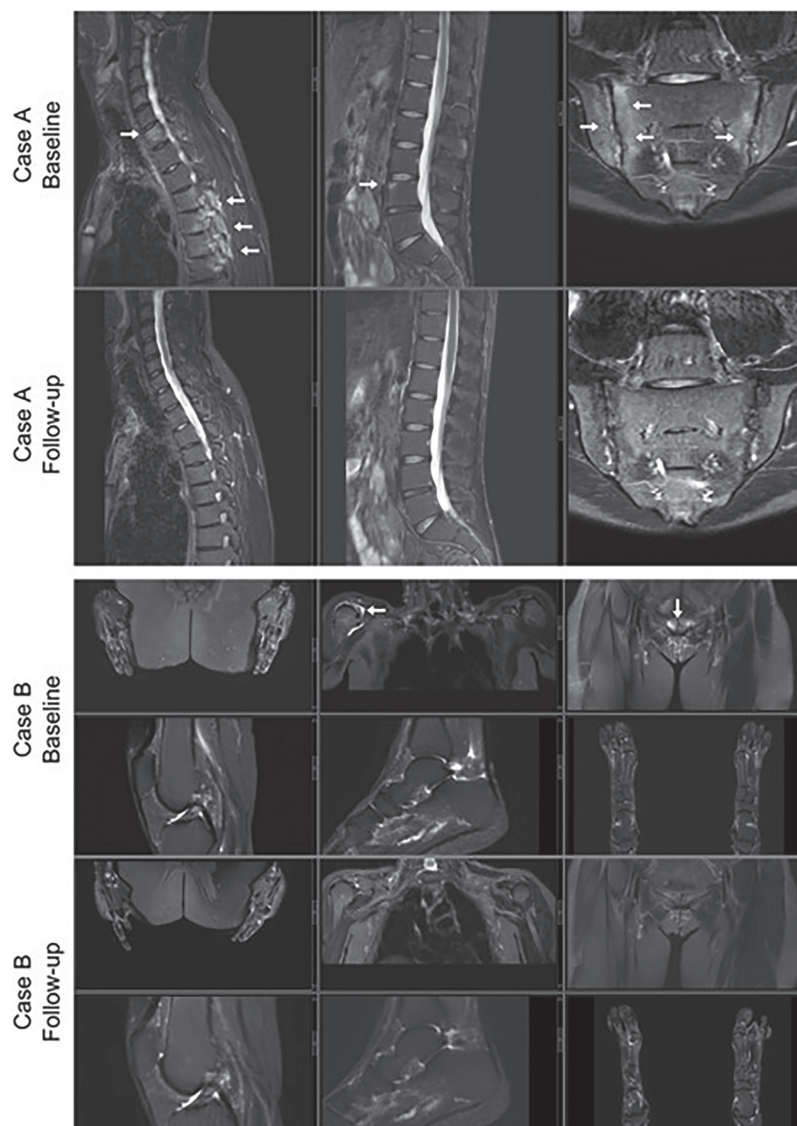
Examples of improvement in axial and peripheral inflammatory lesions documented by whole-body magnetic resonance imaging. Case A: Patient with improvement in axial inflammation. (L-R): Sagittal STIR of upper spine, sagittal STIR of lower spine, and semicoronal STIR of SIJ. Inflammatory lesions in facet joints and lateral parts of vertebral bodies at rib insertions and inflammation of both SIJ at baseline improved during treatment. Case B: Patient with improvement in peripheral inflammation. (L-R): Coronal STIR of hands, coronal STIR of shoulders and anterior chest wall, coronal STIR of pelvis, sagittal STIR of knees, sagittal STIR of ankles, and coronal images of feet. Synovitis and/or effusion in the right glenohumeral (shoulder) joint and osteitis at the pubic symphysis at baseline improved during treatment. Arrows indicate bone marrow edema (inflammation). Reprinted with permission from Krabbe et al.²⁵ SIJ: sacroiliac joints; STIR: short-tau inversion recovery.
